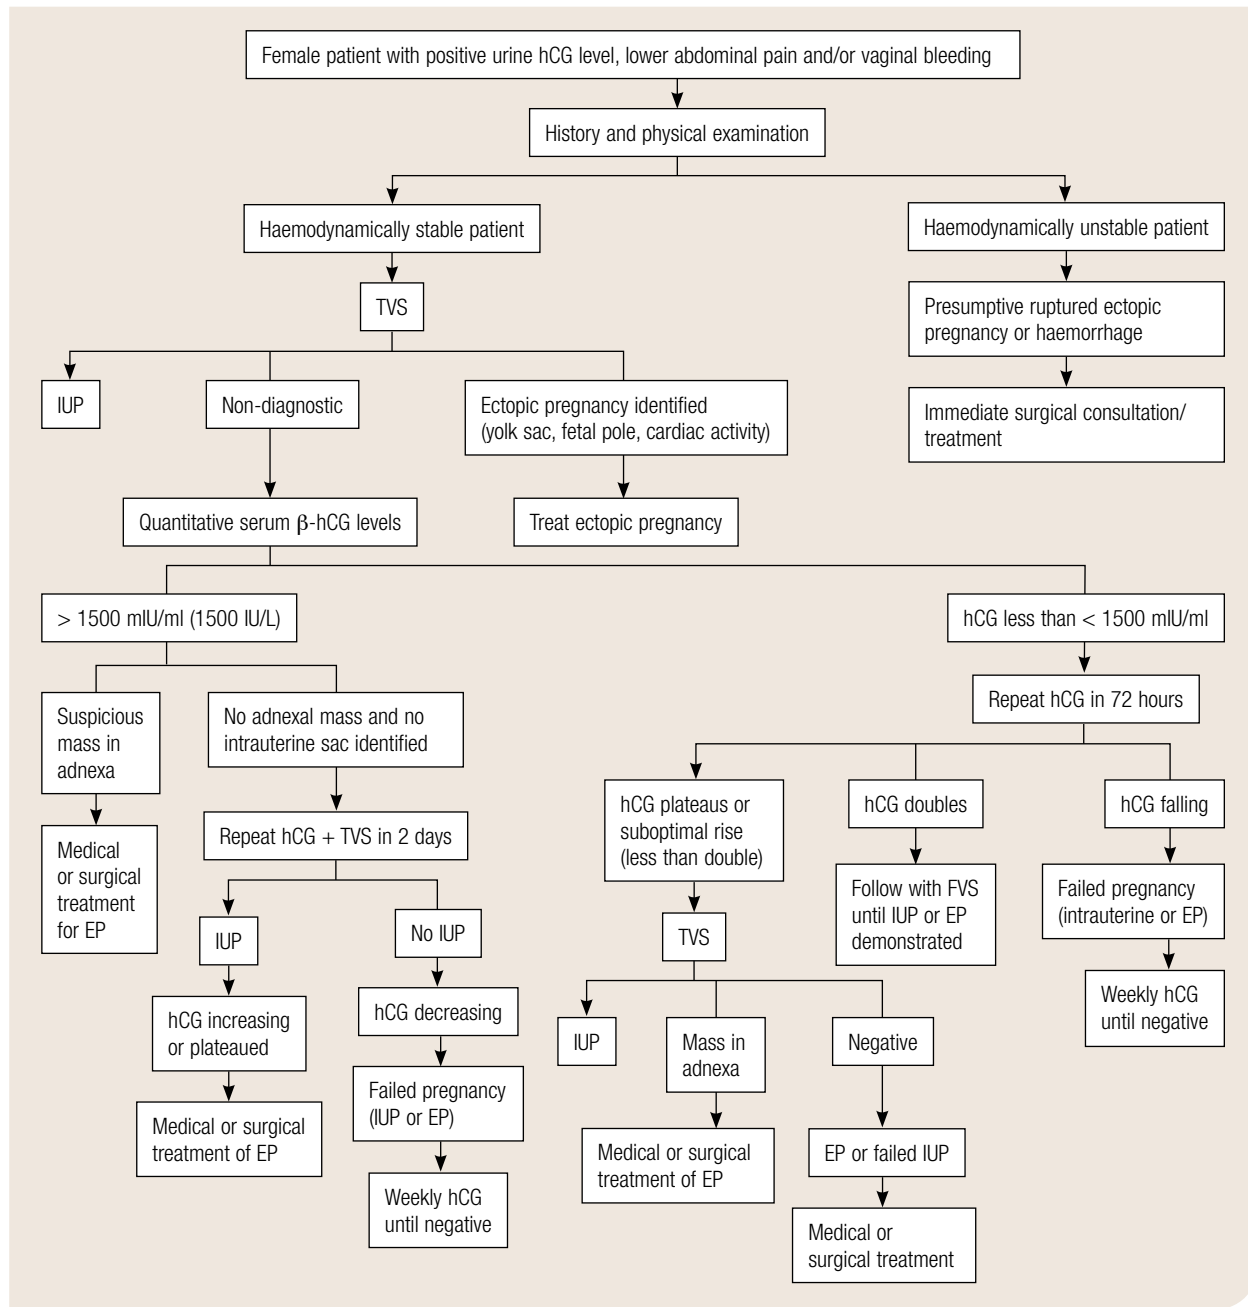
Management of female patient with positive urine hCG level, lower abdominal pain and/or vaginal bleeding. EP: ectopic pregnancy; IUP: intrauterine pregnancy; TVS: transvaginal ultrasound; hCG: human chorionic gonadotropin. Reproduced with permission from: Tulandi T. Clinical manifestations, diagnosis, and management of ectopic pregnancy. In: UpToDate, Basow DS (Ed), UpToDate, Waltham, MA 2013. Copyright © 2013 UpToDate, Inc. For more information visit [www.uptodate.com](http://www.uptodate.com).
